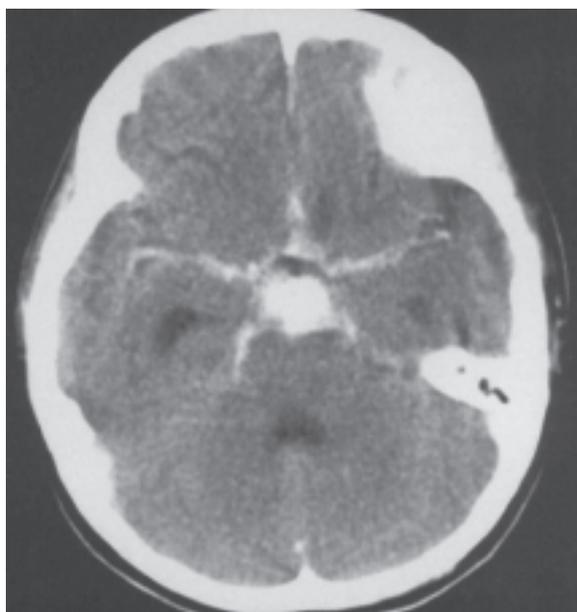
Granulomatous basal meningitis in child with tuberculosis. Enhanced axial CT scan shows enhancing irregular lumpy mass and abnormal enhancement of the basal cistern.
